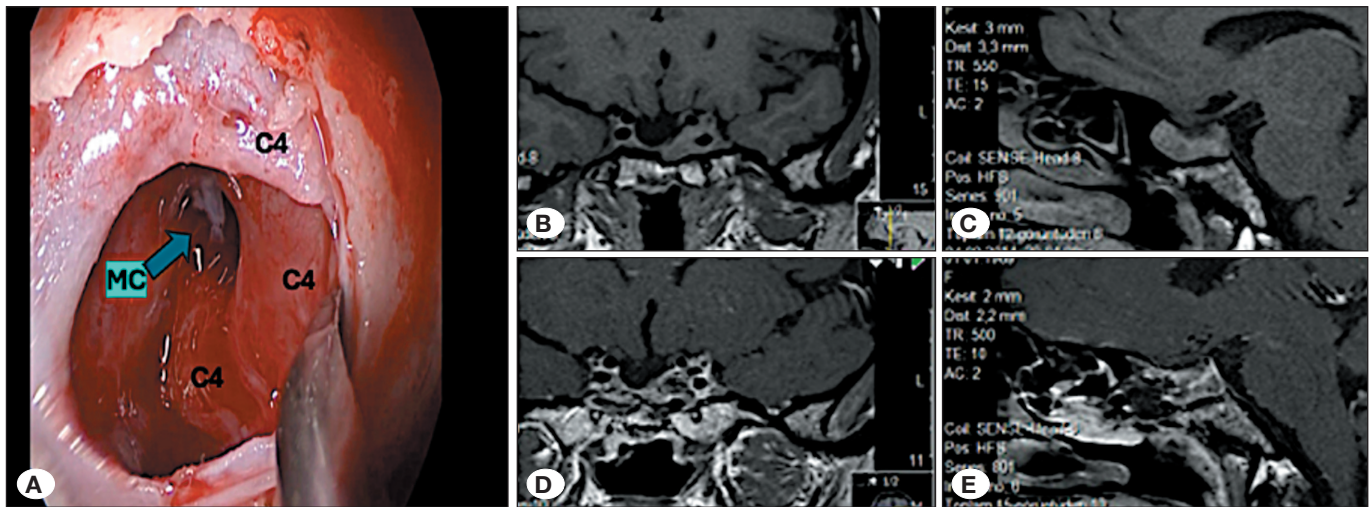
Perioperative (A) demonstration of the medial corridor (MC) in one of the cases from our clinical series, along with pre- (B,C) and postoperative (D,E) magnetic resonance imaging of the same case. C4: cavernous segment of the internal carotid artery.
